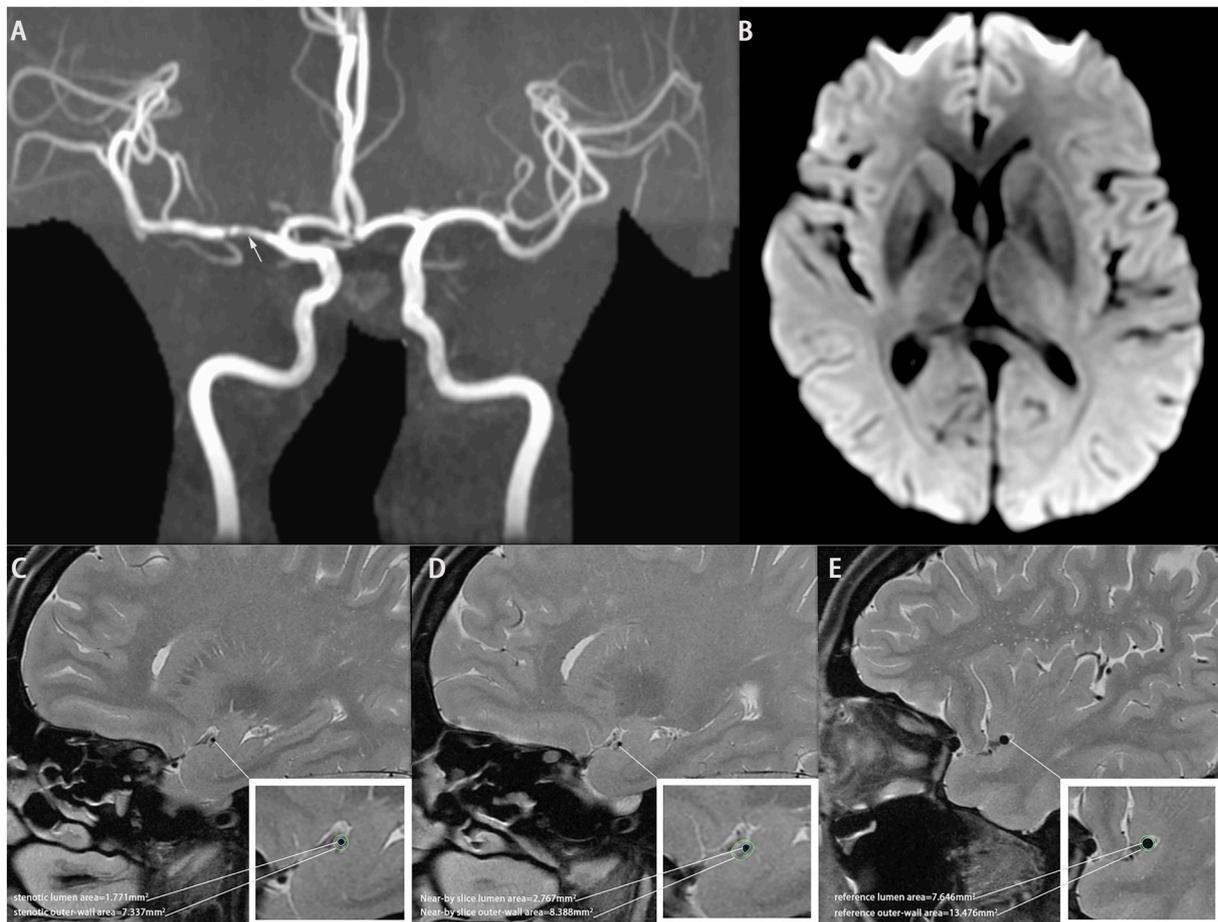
An example of the quantitative measurements of a concentric asymptomatic plaque. A 51 years old woman with hypertension and hyperlipidemia had right MCA stenosis(A) without history of cerebrovascular disease. (B), (C) and (D) are three slices. Quantitative measurements were performed at the maximal stenotic site (B, concentric wall thickening) and the reference site(D) on high-resolution T2-weighted imaging, respectively. Plaque length = 4 slices. SPS = 0.022 (< 2.79) indicates an asymptomatic plaque.
